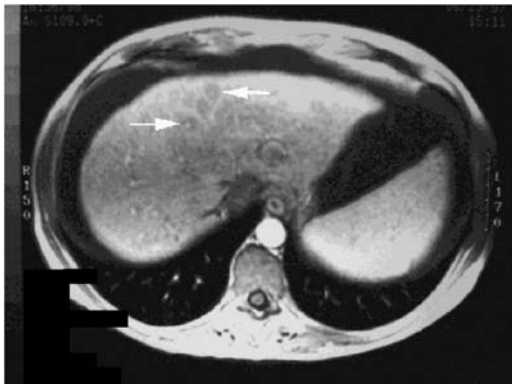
Primary biliary cirrhosis. Transverse T1-weighted MRI reveals round, hypointense lesions surrounding portal veins (arrows), a finding termed the periportal halo sign. (Courtesy of Jeffrey Wenzel, M.D., Southwest Imaging, Dallas, Texas.)
